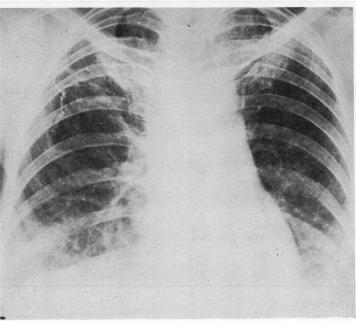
Chest radiograph (a) on admission (August 1973) after clearing of the subcutaneous emphysema, and (b) after treatment with azathoprine showing partial clearing of the shadows (Feb. 1975) (wiring at biopsy site seen in right upper zone).
